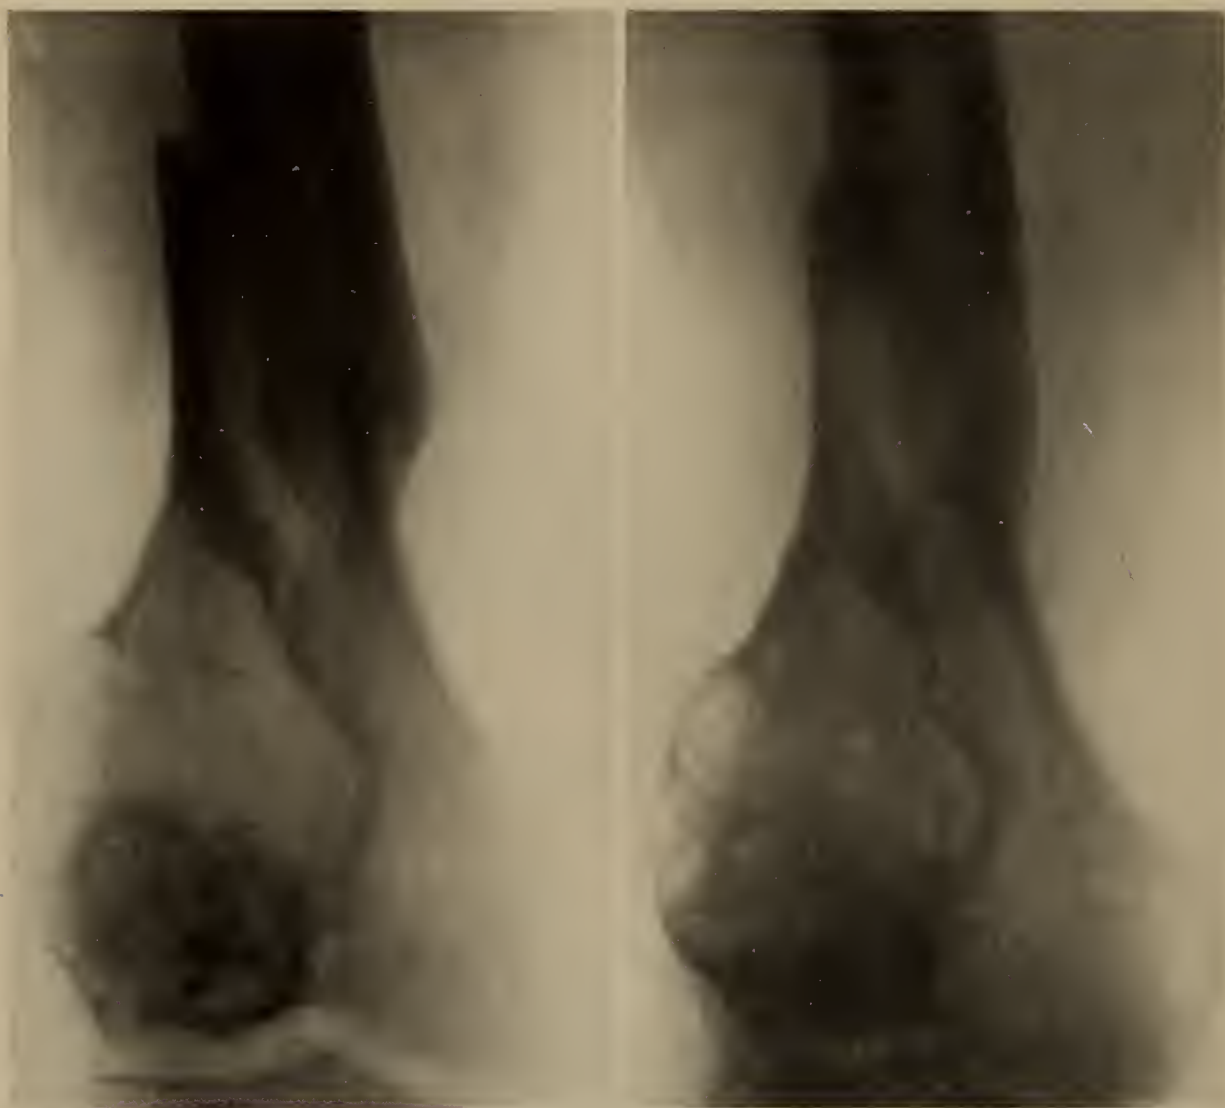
Courtesy Memorial Hospital, New York City. Giant cell tumor with a pathological fracture. Immobilization and radiation therapy instituted. The roentgenogram to right was taken 22 months after the roentgenogram on the left. The function of the limb is completely restored.
